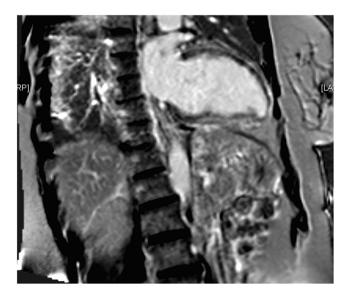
Cardiac magnetic resonance imaging of the patient. Late Gadolinium enhancement visible in the inferior wall of the heart.
